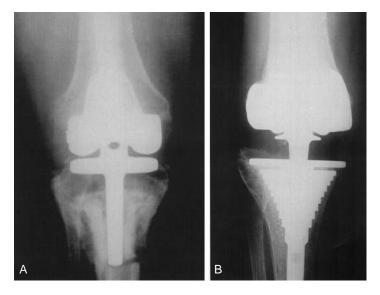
Anteroposterior radiographs were obtained (A) preoperative and (B) 54 months postoperative of a 64-year-old woman, 290 lbs, with a failed Kinematic Rotating Hinge prosthesis. Radiographs obtained after surgery show bone apposition to stepped, textured, metaphyseal sleeves.
